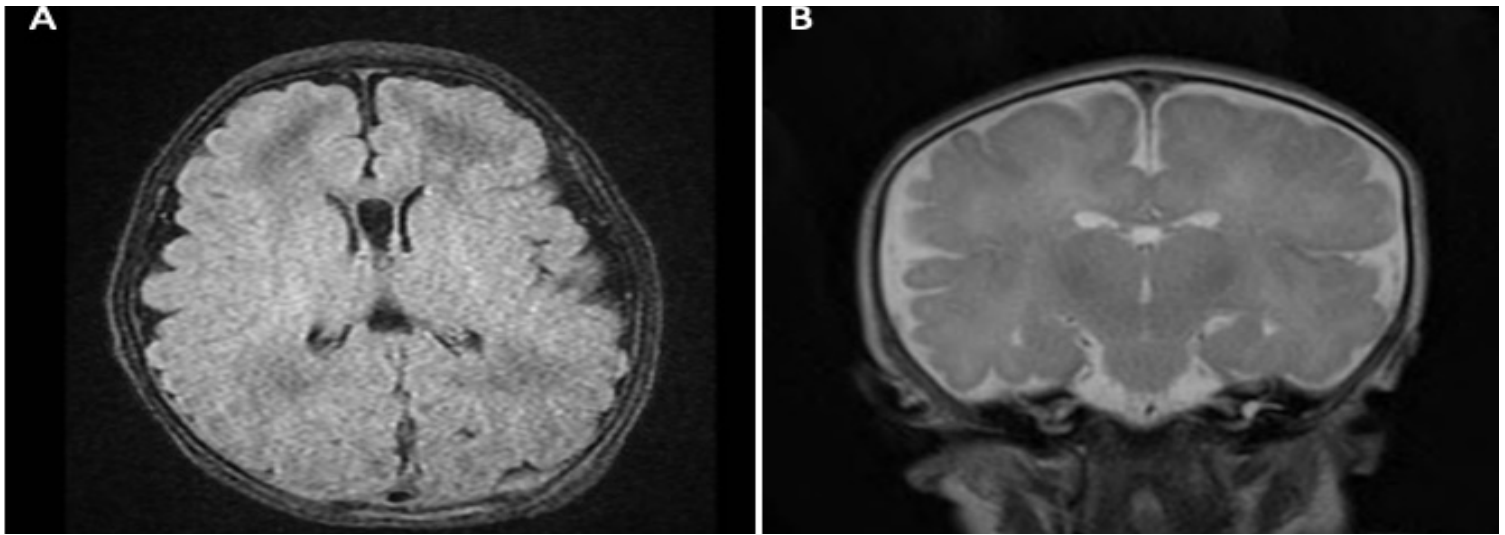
Axial (A) and coronal (B) MRI imaging of the brain demonstrating mild enlargement of the subarachnoid spaces with no extra-axial or subdural effusion and no hydrocephalus. No evidence of parenchymal or intraventricular hemorrhage is seen.
